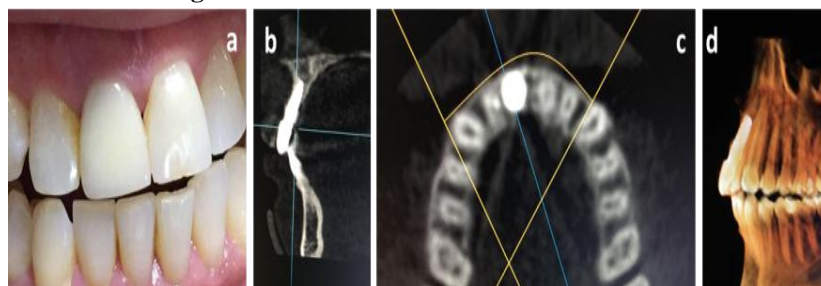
Four Year Clinical and CBCT views
